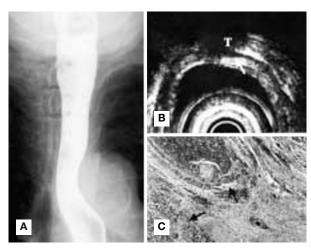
A) Esophagography revealing no change in the esophagus. B) Endoscopic ultrasonography (EUS, 20 MHz) showing interruption of the fourth layer (arrow) by thyroid cancer (T). C) Muscularis propria of the esophagus invaded by papillary carcinoma demonstrating a follicular pattern (arrow).
